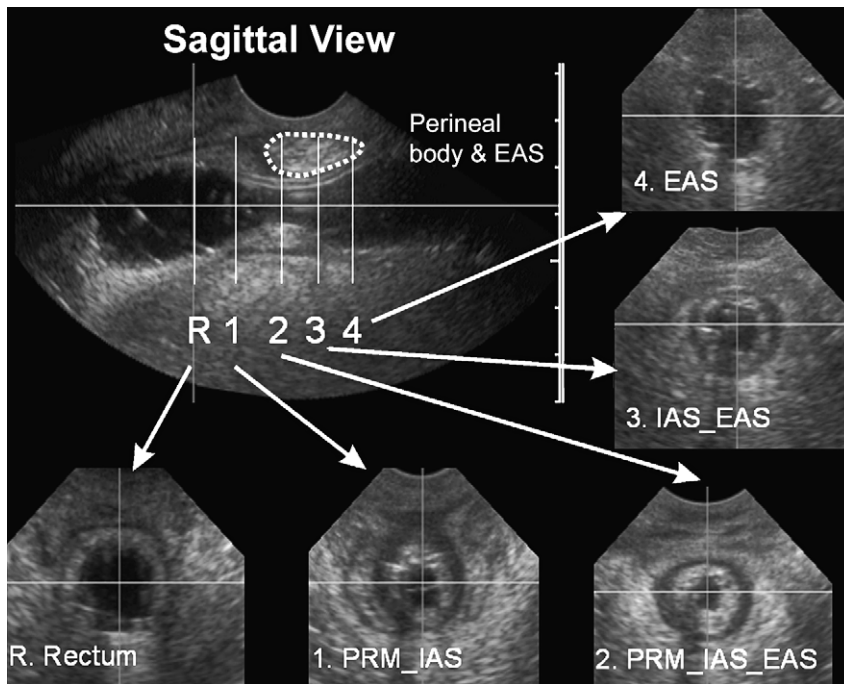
Ultrasound images of the anal canal in the sagittal and axial planes with a water filled bag placed in the anal canal: the sagittal image shows the anal canal along its entire length. Axial images at various locations along the length of anal canal allow visualization of various components of the anal closure mechanism. Axial images at R=rectum, 1=Puborectalis (PRM) & Internal sphincter (IAS), 2 = PRM, IAS, and external anal sphincter (EAS), 3 = IAS & EAS, 4 = EAS only. Obtained from author.
